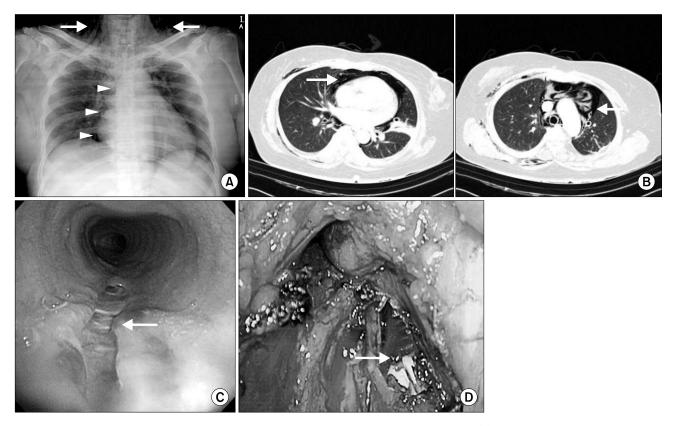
A chest film shows a marked pneumomediastinum and subcutaneous emphysema of neck (A) and computed tomography scans of chest show marked pneumomediastinum and pneumopericardium but does not show lesions indicating tracheal or esophageal injury (B). Bronchoscopy reveals a 4-cm posterior membranous tracheal laceration approximately 5 cm from the carina (C). Intraoperative photographs show membranous tracheal linear laceration about 4 cm in length (D).
